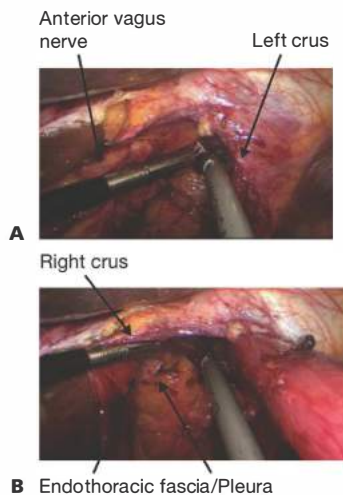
• A,B. Demonstration of proper range of proximity to the esophagus during ultrasonic dissection. A. View from left, near esophagus. B. View from right, approaching endothoracic fascia and pleura.
